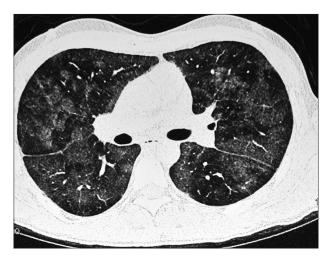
CT scan showing bilateral ground glass appearance and septal thickening
